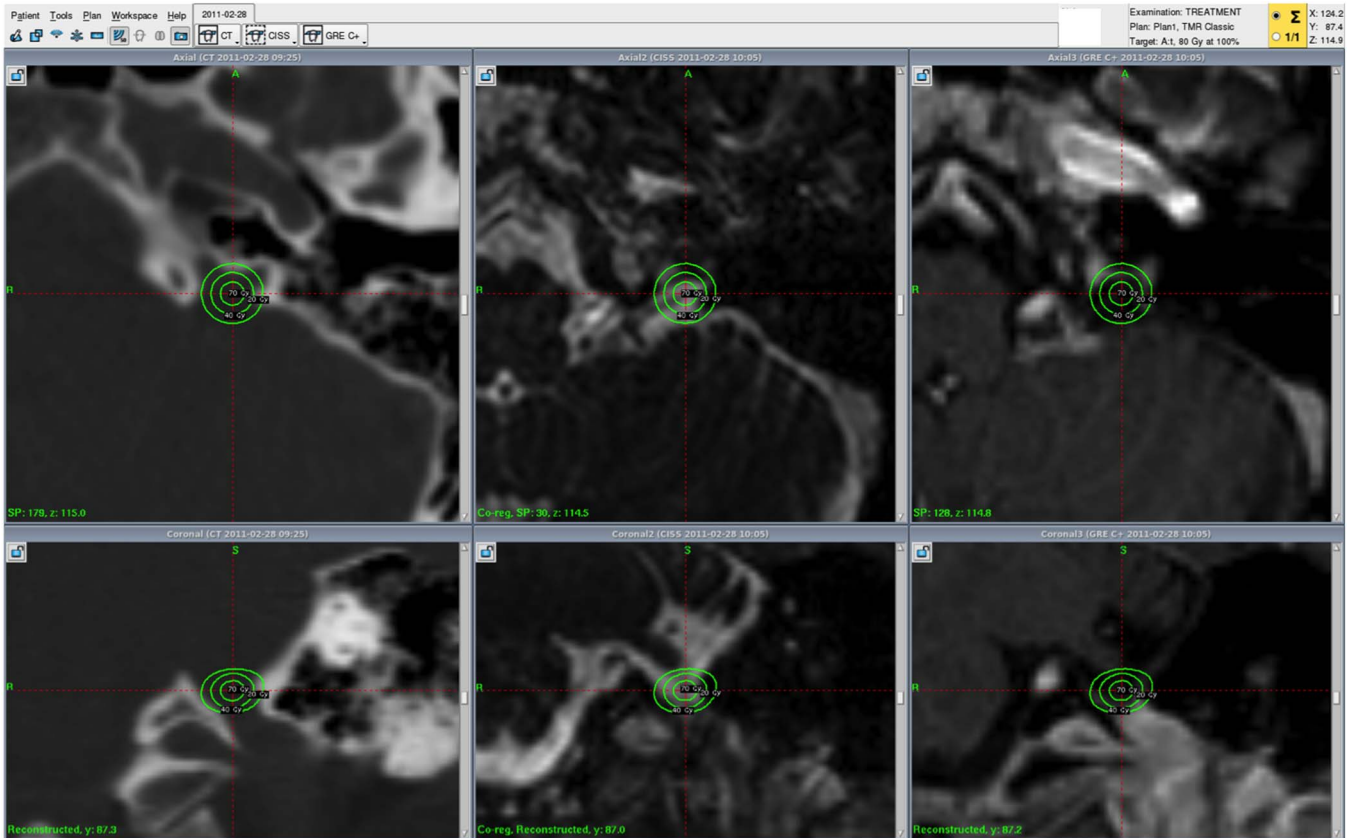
Leksell GammaPlan snapshot of the treatment plan. The treatment isocenter is shown at the glossopharyngeal meatus. Upper row shows the axial plane; lower row, the coronal plane. Left column shows CT images; middle column, constructive interference steady-state MIs; right column, contrast-enhanced magnetization-prepared rapid gradient-echo MRIs.
